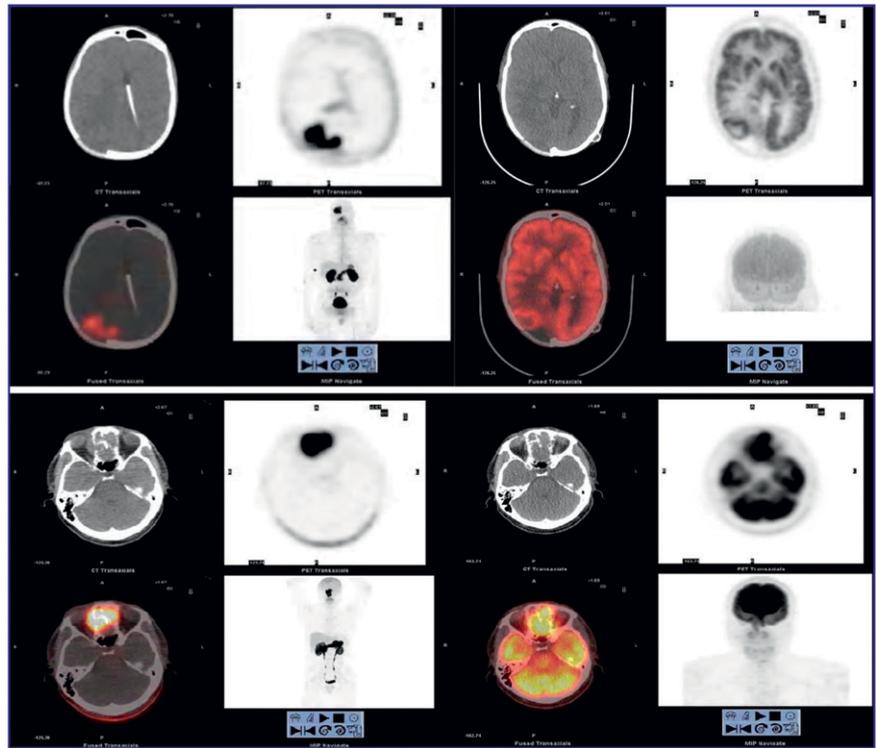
Comparative BAY9409392 (left) and FDG (right) axial PET/CT images of: (top) 63-y-old man with recurrent brain metastases to the right parieto-occipital region from lung cancer; (bottom) 45-y-old man with newly diagnosed nasopharyngeal cancer.
